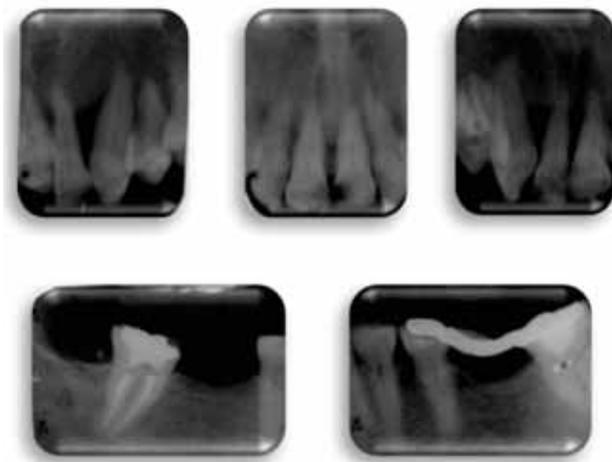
Initial radiographic characteristics.
